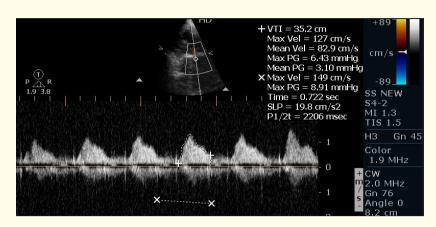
Continuous wave Doppler across bioprosthetic valve at tricuspid position showing a mean gradient of 3 mmHg after resection of right ventricular mass.
